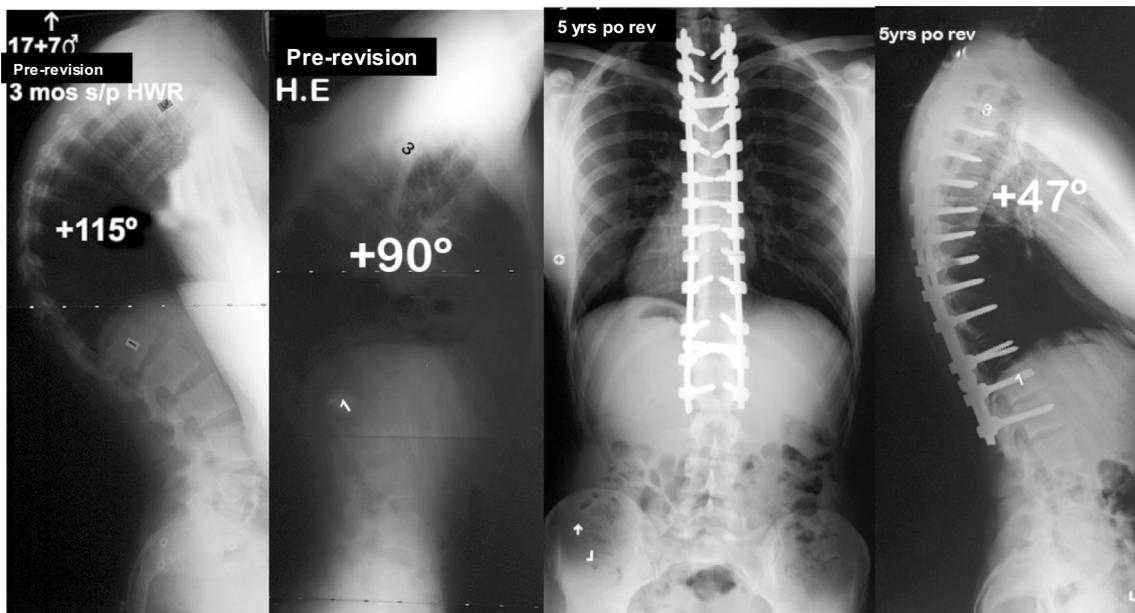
Comparison X-rays showing pre- and 5-year postoperative X-rays after a revision PSF with PCOs x9. The combination of good bone and solid screws allowed for good deformity correction
